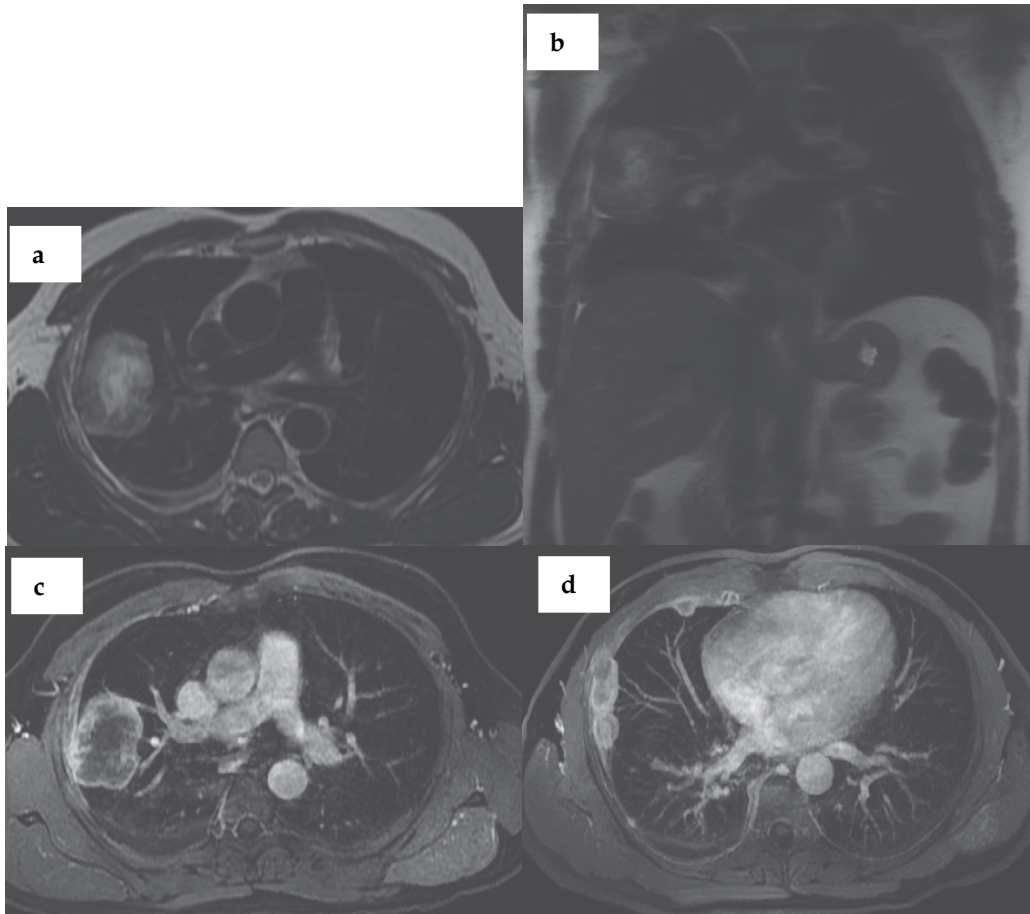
A 62 year-old male with small cell lung cancer with pleural involvement. Axial double IR black-blood spin-echo MR (a) and coronal T2-weighted single-shot fast spin-echo (b) images clearly showed a pulmonary mass in the right upper lobe. Post contrast T1-weighted 3D-GRE images (c, d) defined the lesion's vascular characteristics and as well as pleural involvement.
